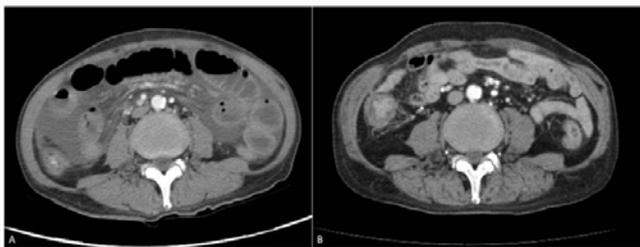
Axial contrast-enhanced CT image revealed segmental small bowel wall thickening and dilatation.
